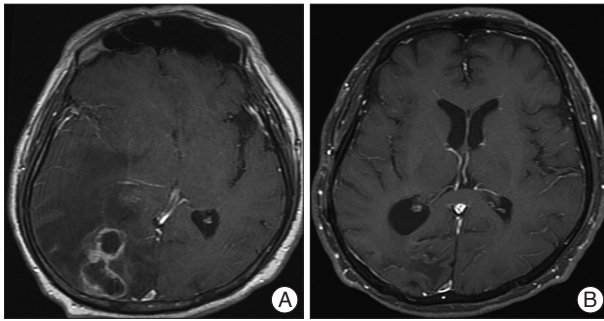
A : Brain magnetic resonance (MR) imaging. A multiloculated rim-enhancing lesion with perilesional edema is observed in the right occipital lobe with a significant mass effect. B : Follow-up MR imaging. There is no residual enhancing lesion and no edema in the right occipital lobe at 2 months after operation.
